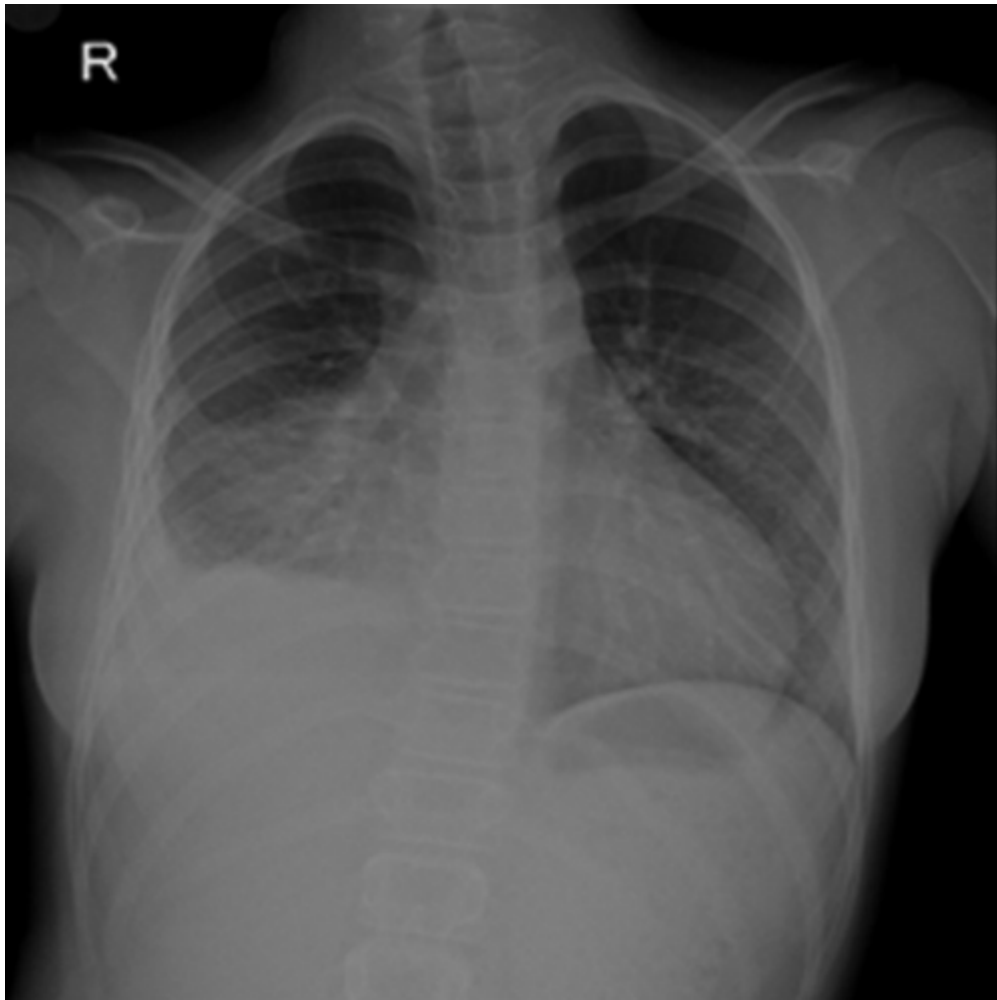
Chest radiograph from 26 February 2024 showing a large opacity projected over the right lung base, effacing the right heart border and associated with a large predominantly subpulmonic effusion. No hilar adenopathy is evident. [↩](#)
